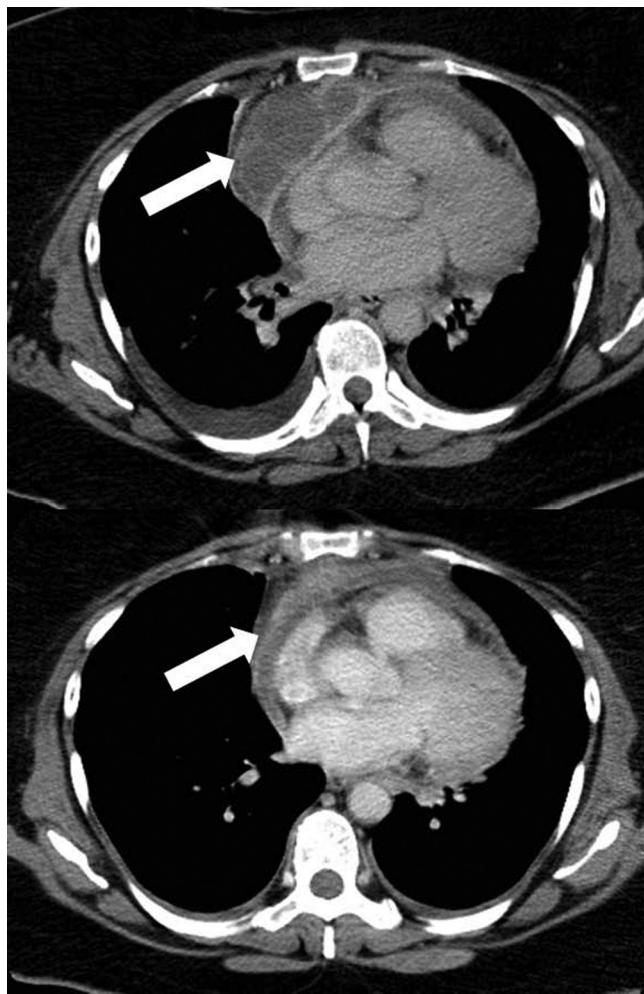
CT scan of the chest of a patient with widespread mediastinal (arrows) and neck abscesses prior to (upper panel) and after (lower panel) percutaneous drainage. The largest of these measured 3.2 by 7.2 by 8 cm prior to drainage (arrow, upper panel).
